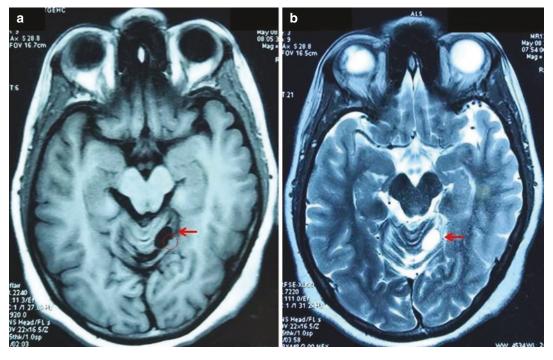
MRI brain of a patient with VHL. Oval shaped lesion (arrow) hypo intense on T1 (a) and hyper intense on T2 weighted image (b) suggestive of a cyst. Tiny hyper
